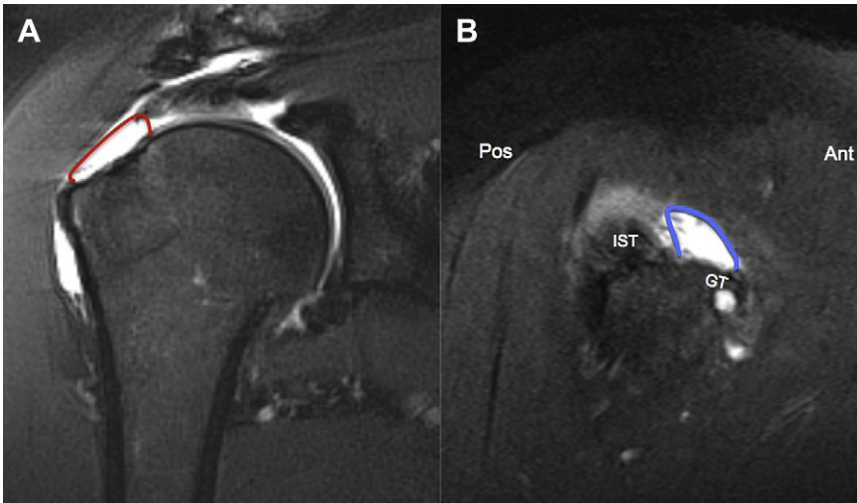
(A, B) Anterior L-shaped tear. An anterior L-shaped tear is seen within the supraspinatus tendon on coronal (A) and sagittal (B) oblique fat-suppressed T2-weighted images of the right shoulder. The anterior L-shape is defined by a long longitudinal component (*red line*) compared with a narrow transverse component (*blue line*) as well as the location within the anterior half of the rotator cuff insertion onto the greater tuberosity (GT). IST, infraspinatus tendon.
